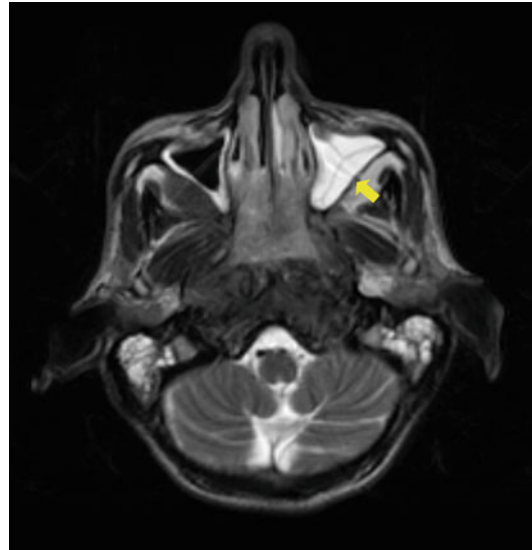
Axial T2 MRI image of paranasal sinuses showing tumor originating in the nasopharynx with extension into the nasal cavity with retained secretions in the left maxillary sinus (yellow arrow)
